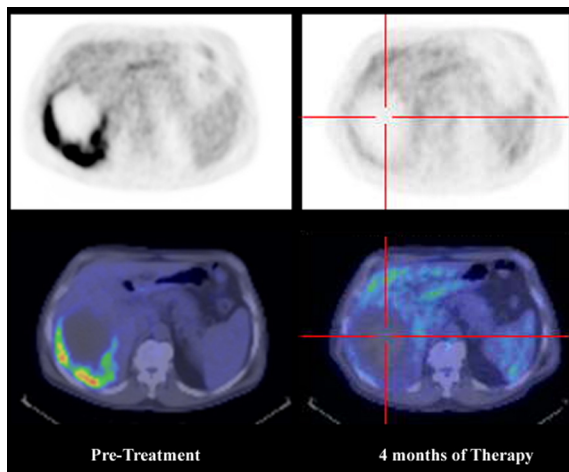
Representative, co-registered FDG PET images (above) and fused PET/CT images (below) in the transaxial plane are demonstrated from a patient with a large, centrally necrotic GIST tumour at baseline (left) and 4 months after commencing imatinib (Glivec) (right). The hypermetabolic rim of the tumour had demonstrated a marked reduction in uptake within 1 week of commencing therapy (not shown) but the hypodense lesion on CT had increased slightly in size on follow-up. An ongoing metabolic response allowed the patient to remain on therapy with ongoing symptomatic benefit.
